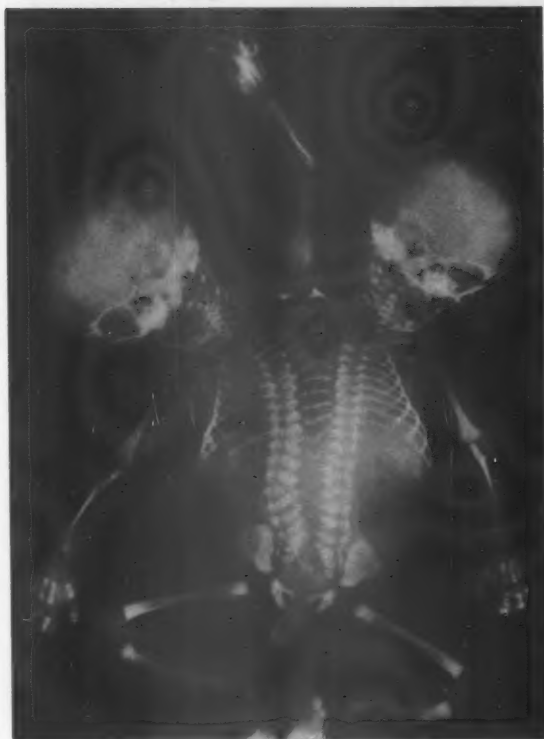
Roentgenological picture of the monster showing the skeletal anomalies.
